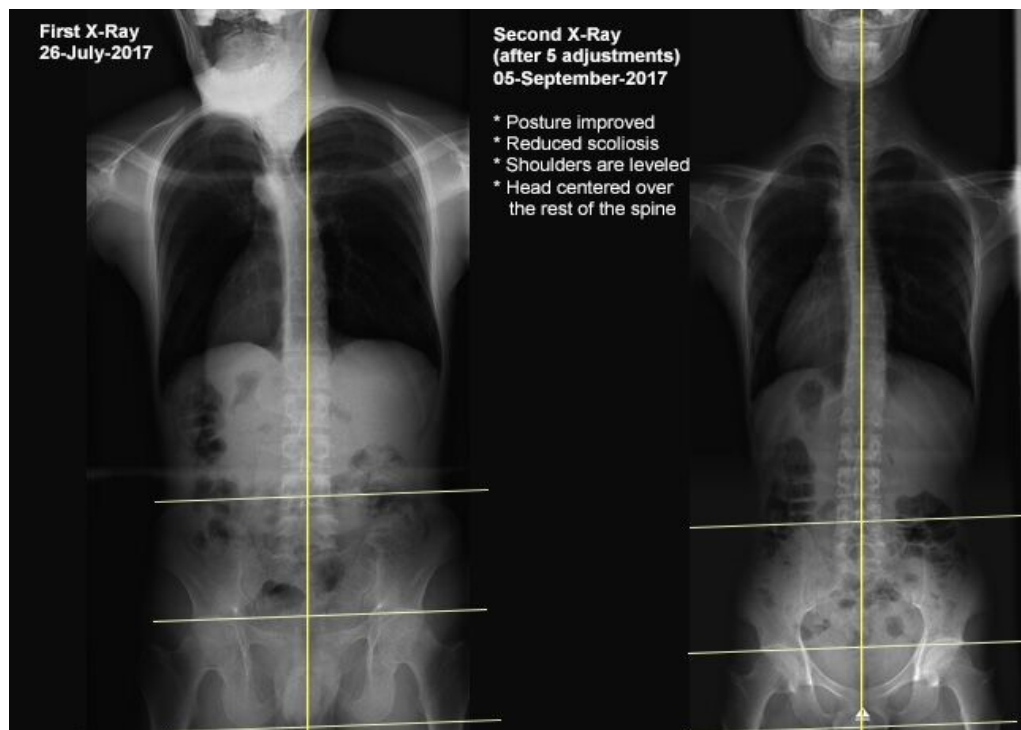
Comparative X-Ray (A-P View)
